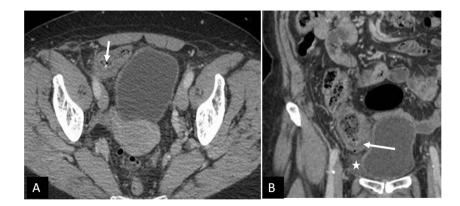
Postcolonoscopy microperforation of the cecum in a 56-year-old woman. Axial (a) and coronal (b) contrast-enhanced CT shows few air specks in the edematous cecal wall (*long arrow*) and adjacent free fluid (*asterisk*). Note the presence of high-density clips in the cecal wall (*short arrow*) polypectomy and 0.1 % with biopsy or polypectomy) [29]. Rectosigmoid colon is the most common site for perforation. Patients with perforation present with abdominal pain and distension, fever, and leukocytosis. Perforations of intraperitoneal colonic segments will more often lead to free intraperitoneal air and fluid, whereas perforation of the ascending colon, descending colon, and rectum is more likely to result in extraperitoneal air and fluid. Large amount of air can be detected on plain radiographs. CT will be required to detect small amount of free air and fluid collection especially in contained perforation [30]. Management is based on the site and severity of perforation, peritoneal contamination, and hemodynamic status [31].
